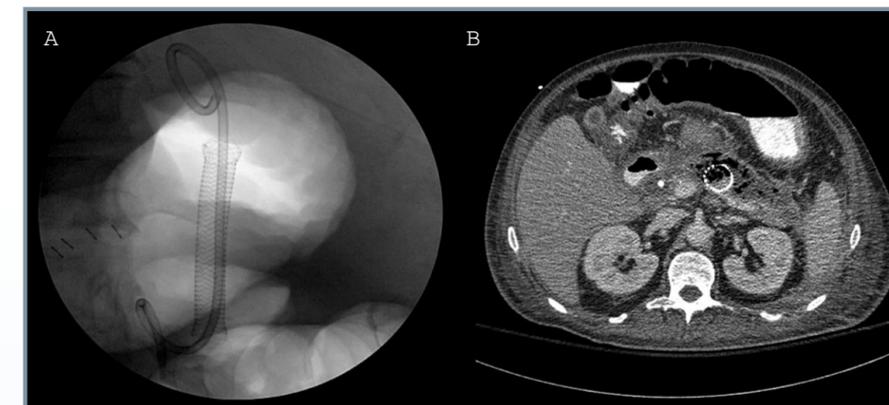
(A) Fluoroscopic view of fully covered SEMS with double pigtail plastic stent. (B) CT image of esophageal stent within PFC.
